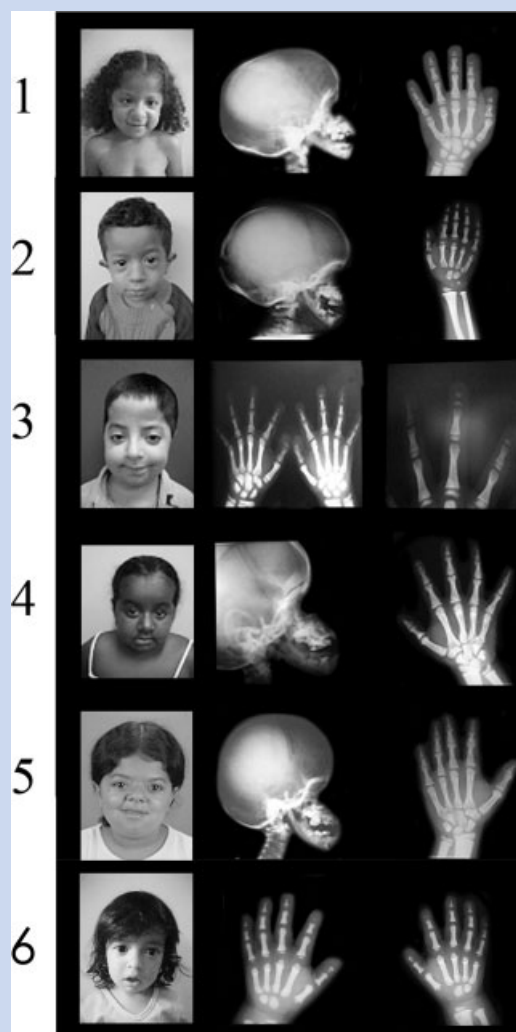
Frontal view of the patients with pycnodysostosis showing high cranial vault, proptosis, and micrognathia with their corresponding cranial and/or hand X-rays (bone sclerosis, obtuse angle of the mandible and acro-osteolysis).
